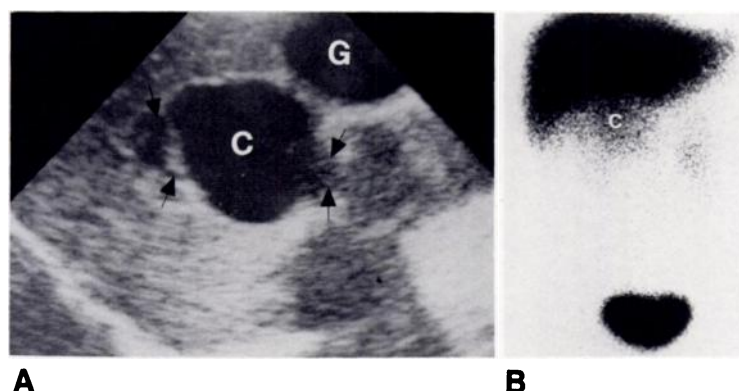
Choledochal cyst. A, Longitudinal sonogram through liver. Dilated cystic structure (C) appears to communicate with dilated bile ducts (arrows). Gallbladder (G) is somewhat distended. B, Hepatobiliary scintigram 8 hr after injection of ^{99m}Tc -DISIDA. Tracer accumulation within choledochal cyst (C). Tracer activity within kidneys and bladder, but no activity within gastrointestinal tract.
